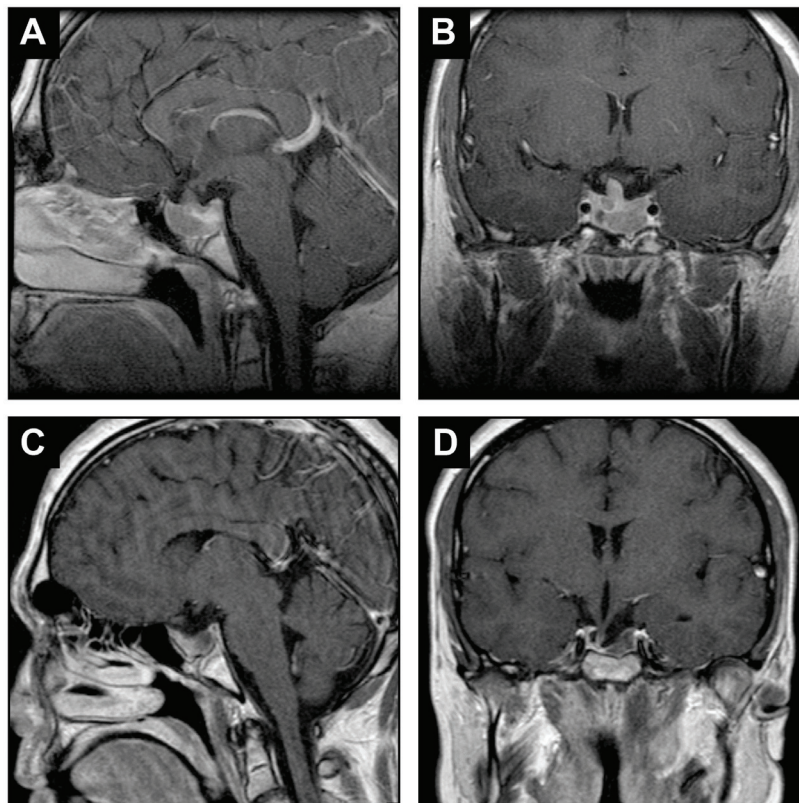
Magnetic resonance imaging: pre-treatment (A) sagittal T1 and (B) coronal T1, and 2 years post-treatment (C) sagittal T1 and (D) coronal T1.
